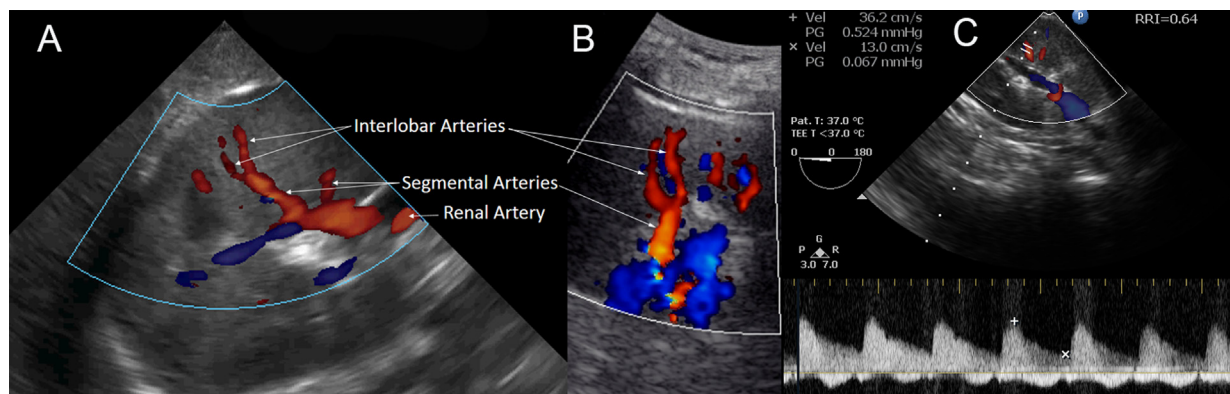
Examples of color-flow Doppler imaging of transesophageal (A) and translumbar USG (B) and pulsed-wave Doppler imaging (C) obtained by transesophageal echocardiography.
